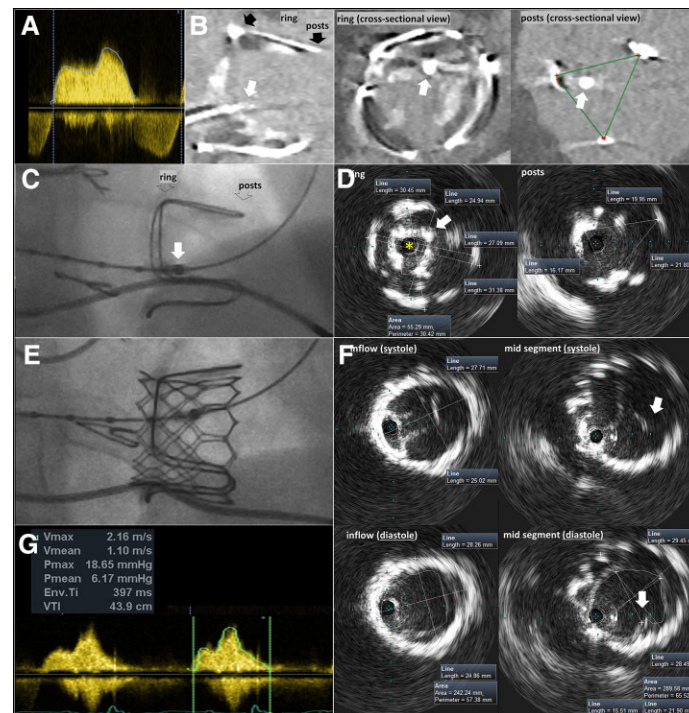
Baseline trans-valvular transthoracic echocardiography Doppler (A), computed tomography angiography (B), fluoroscopy (C) and intravascular ultrasound images (D) of failed 31 mm Carpentier–Edwards bioprosthesis. Corresponding fluoroscopy, intravascular ultrasound, and transthoracic echocardiography Doppler results recorded post valve-in-valve transcatheter tricuspid valve replacement using the SAPIEN 3 29 mm (E–G, respectively).
